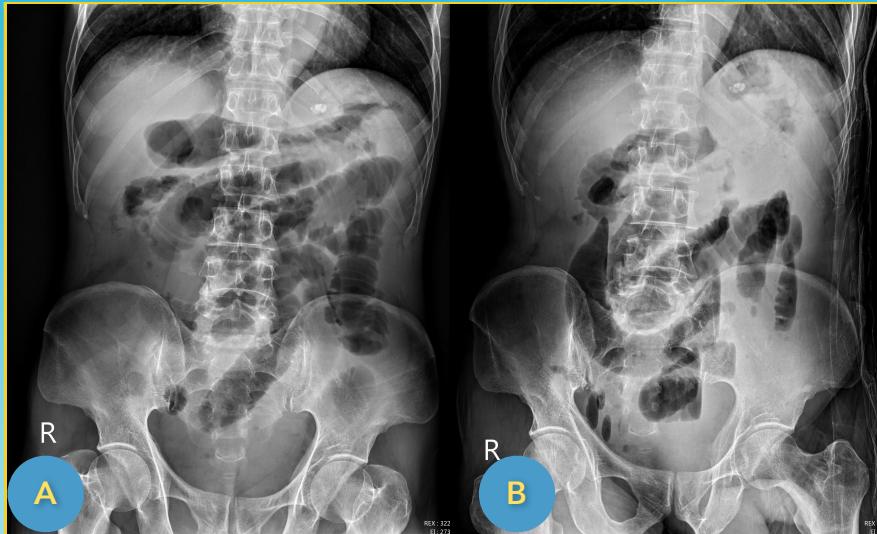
Plain X-Ray Film of the Abdomen of the Case.
